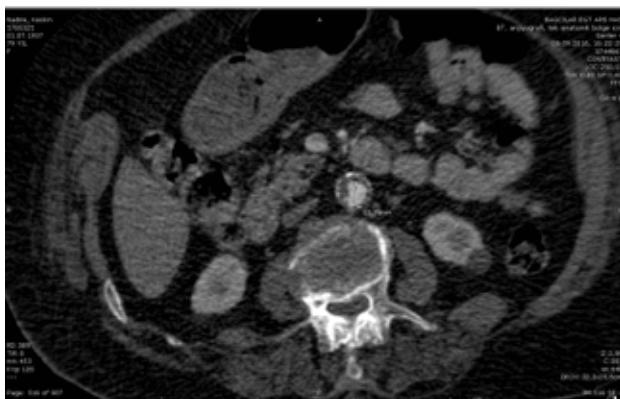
Preoperative CT angiography showing severe stenosis of infrarenal abdominal aorta.
